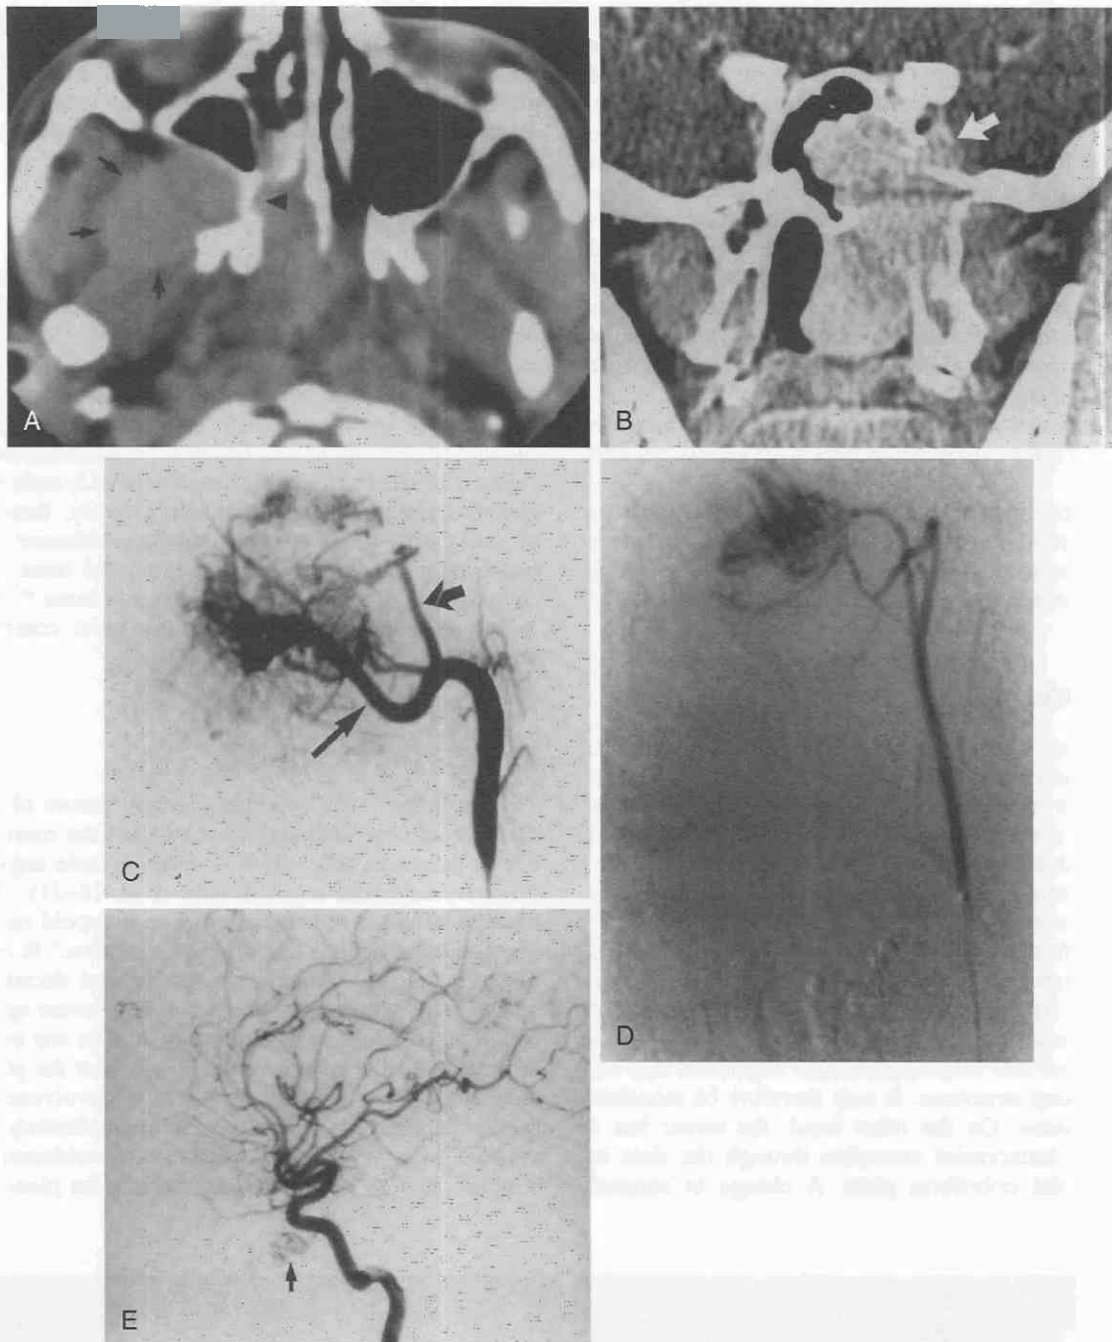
Juvenile angiofibroma. Axial post-contrast-enhanced CT scan (A) through the paranasal sinuses reveals an enhancing mass within the infratemporal fossa (arrows) that extends into and expands the pterygopalatine fissure (arrowhead). In the coronal view (B) there is extension into the nasal cavity with destruction of the pterygoid plates and extension into the sphenoid sinus. There is also lateral extension into the region of the cavernous sinus with bone destruction (arrow). These masses are usually supplied by terminal branches of the sphenopalatine artery (C, long arrow). In this particular patient, because of the extension intracranially, there is supply from dural vessels such as the middle meningeal artery (C, short arrow). In addition, there is also supply from other external carotid branches such as the ascending pharyngeal (D). In patients with intracranial extension or with extension into the clivus, there may be supply from branches of the internal carotid artery (E, arrow).
